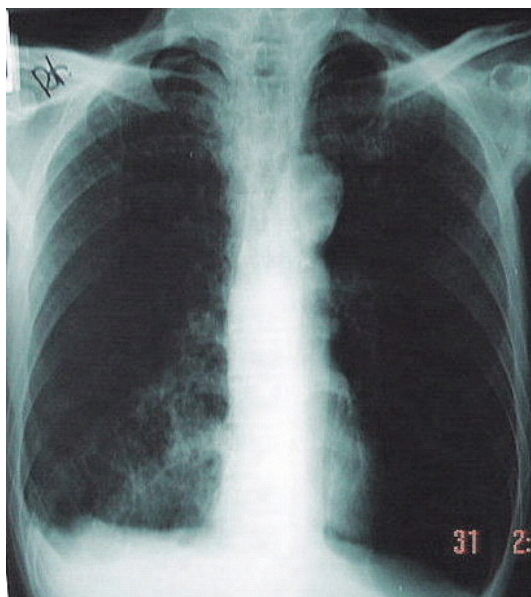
Chest radiograph on the first day of admission showing some infiltrations of the right lower lobe
